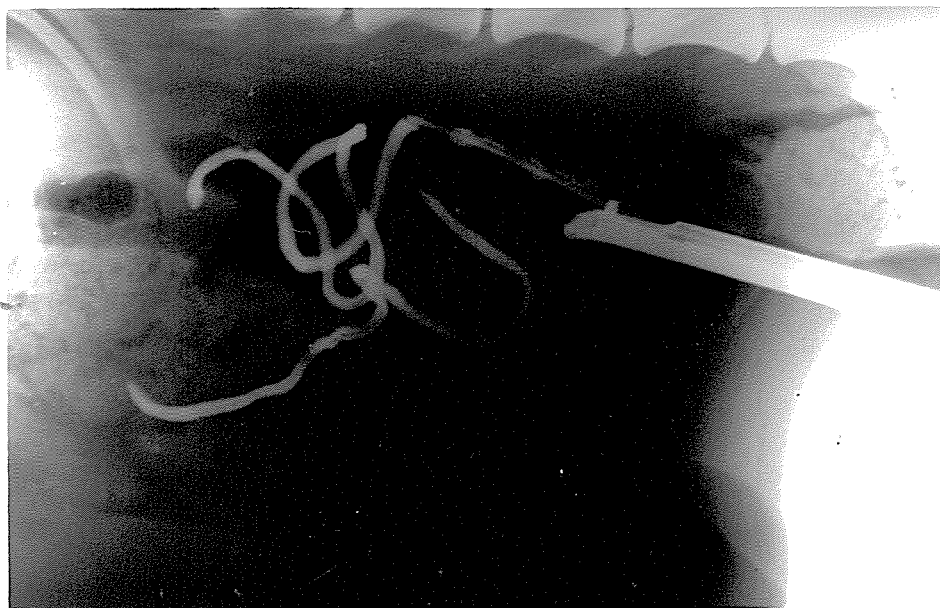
Radiographs demonstrating the site of insemination using the “Endoscopic” technique.
